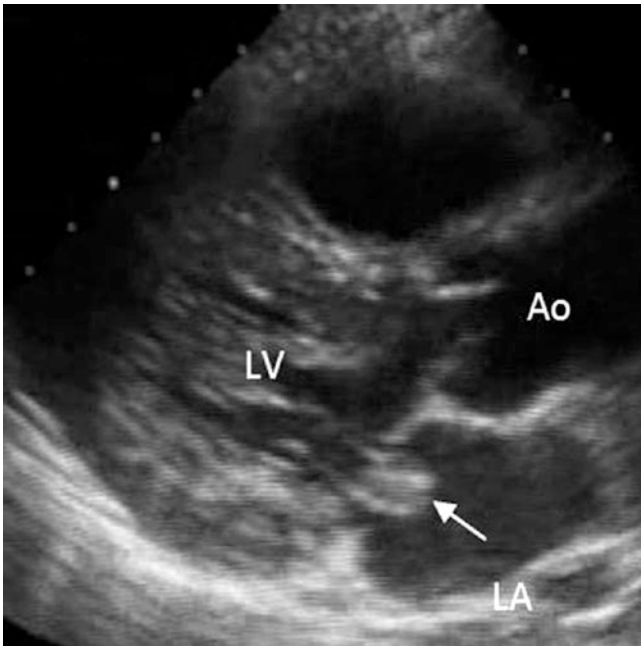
Parasternal long axis view POC imaging of a 60-year-old patient who presented with acute embolic stroke. A highly mobile roundish mass (*arrow*) with moderate size attaches to the atrial aspect of the mitral valve, consistent with a diagnosis of papillary fibroelastoma. It is prudent to exclude infective endocarditis in these cases. *LA* left atrium, *LV* left ventricle, *Ao* aorta
